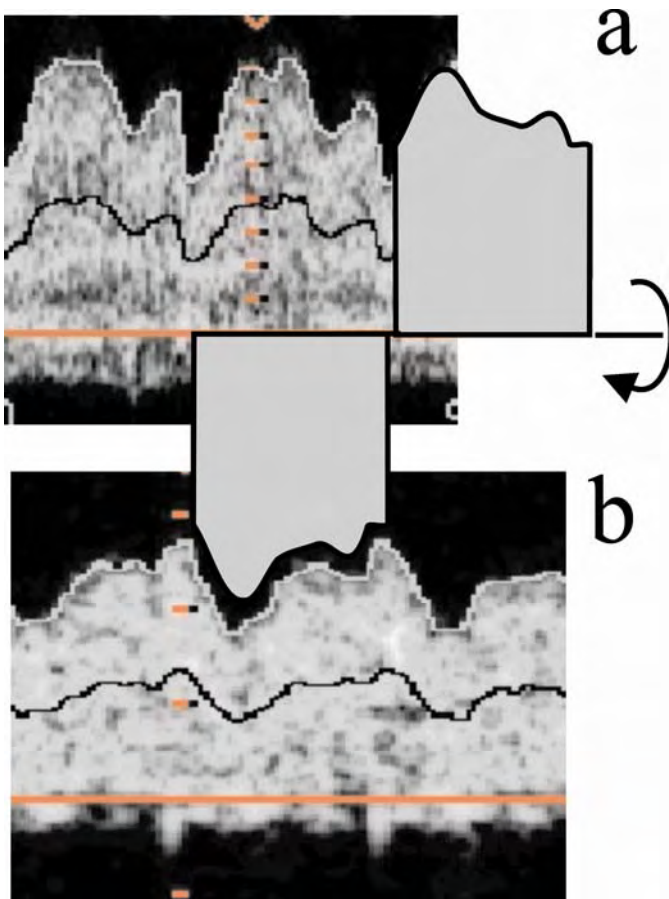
Pulsed Doppler recording at 28+5 weeks of gestation. The pulsatility pattern in the left portal branch (b) is an inverse image of the ductus venosus (a).
